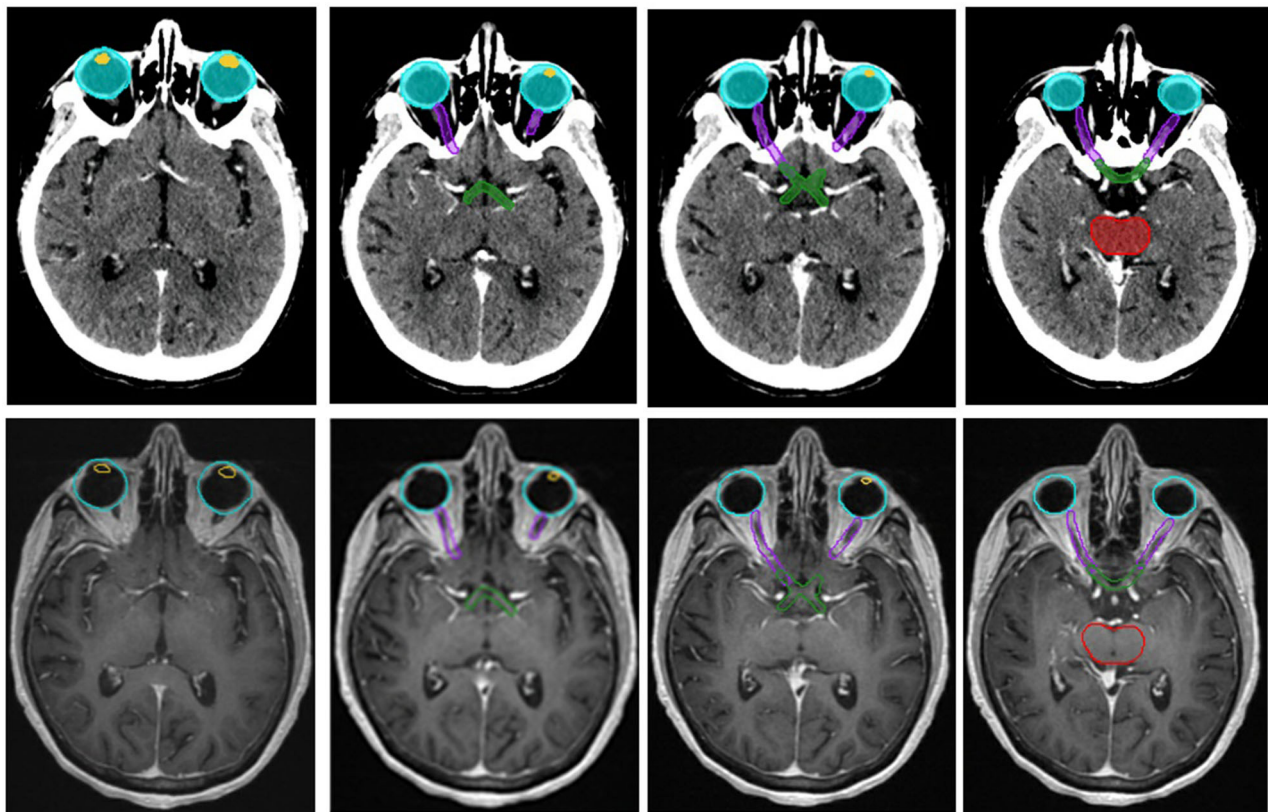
Organs at risk (OARs) defined on a planning CT and corresponding T2-weighted MR images. The included OARs are the lenses, yellow, the eyes, aqua, the optic nerves, purple, the optic chiasm, green, and the brain stem, red.
